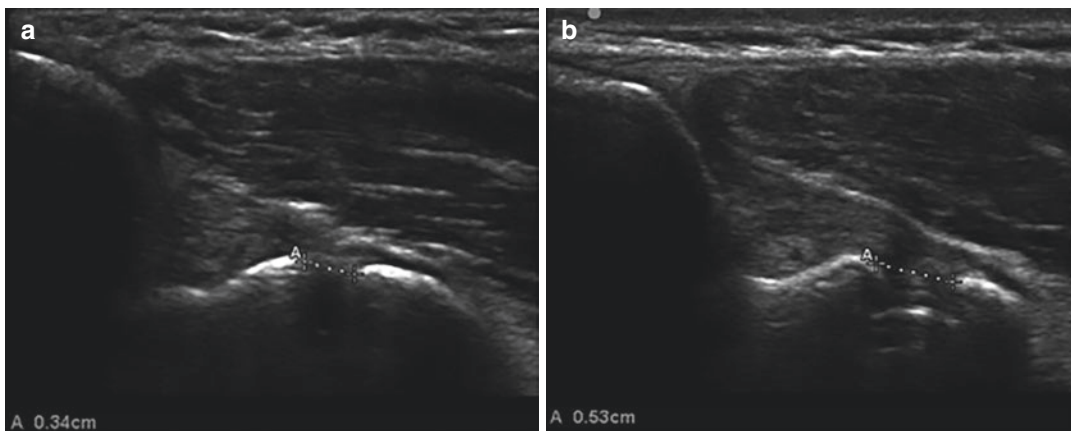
Stress ultrasound demonstrating (a) the width of the ulnohumeral joint at rest; (b) the width of the ulnohumeral joint with applied valgus stress
